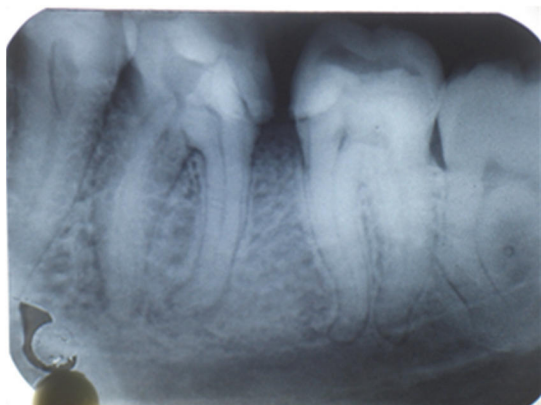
Target X-ray image of tooth 46 in the patient. The condition of the tooth before treatment.
